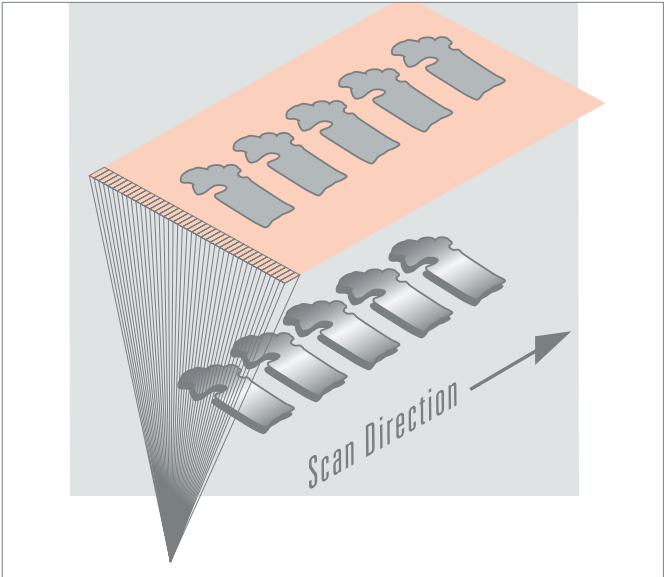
CT and fan-beam DXA share a similar imaging geometry and obtain spine images through linear gantry motion along the length of the patient.
